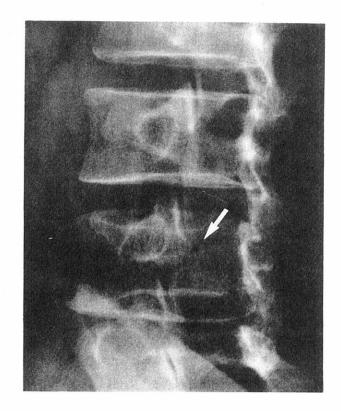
Case 2: Right posterior oblique radiograph of 9 August 1976 shows a new right-side pars interarticularis defect (arrow) of L4
